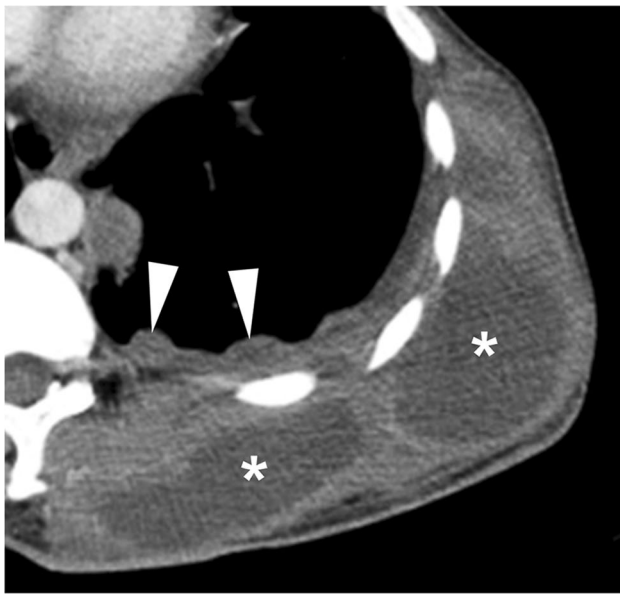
Contrast-enhanced axial computed tomography image on soft tissue window setting demonstrates subcutaneous abscesses (*asterisks*), also known as empyema necessitans and nodular pleural disease (*arrowheads*) in a 14-year-old boy with complicated thoracic tuberculosis
